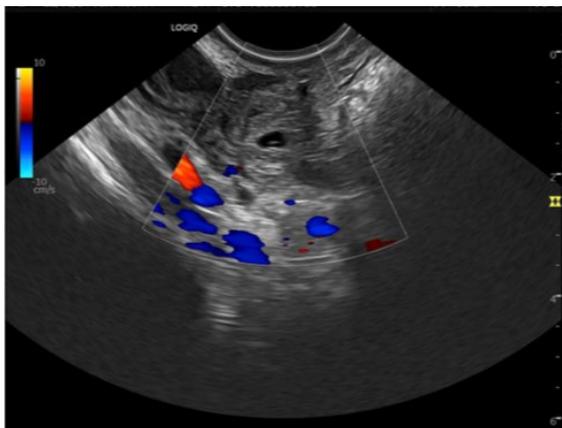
Ultrasound image of the tubal ectopic gestation in the right tube
